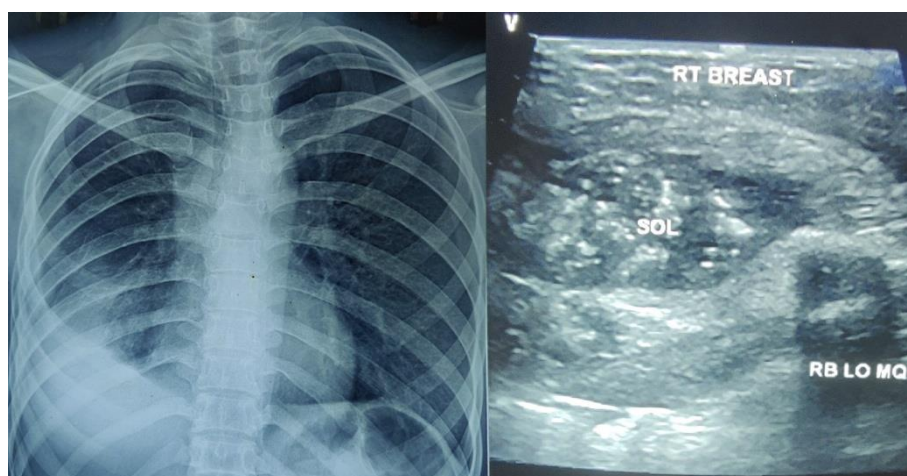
Left picture showing Chest Xray of the patient with right sided homogenous opacity; Right picture showing a heterogeneously enhancing space occupying lesion (SOL) in the right breast.
